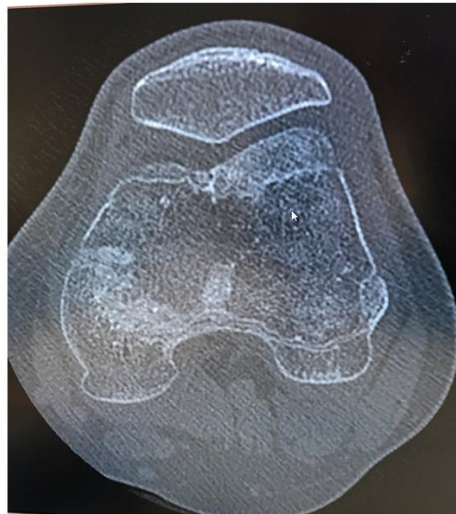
CT scan 12 weeks post-surgery demonstrating the OCD lesion has healed
